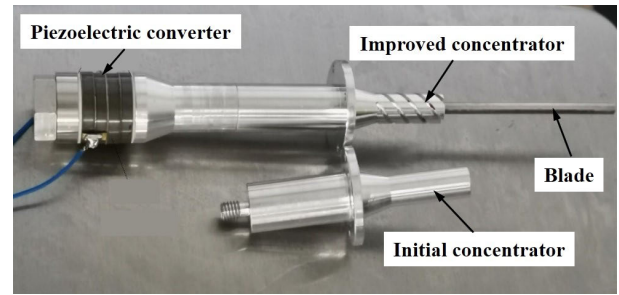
The fabricated prototypes of the designed hemostatic ultrasonic scalpel and conventional ultrasonic scalpel.
